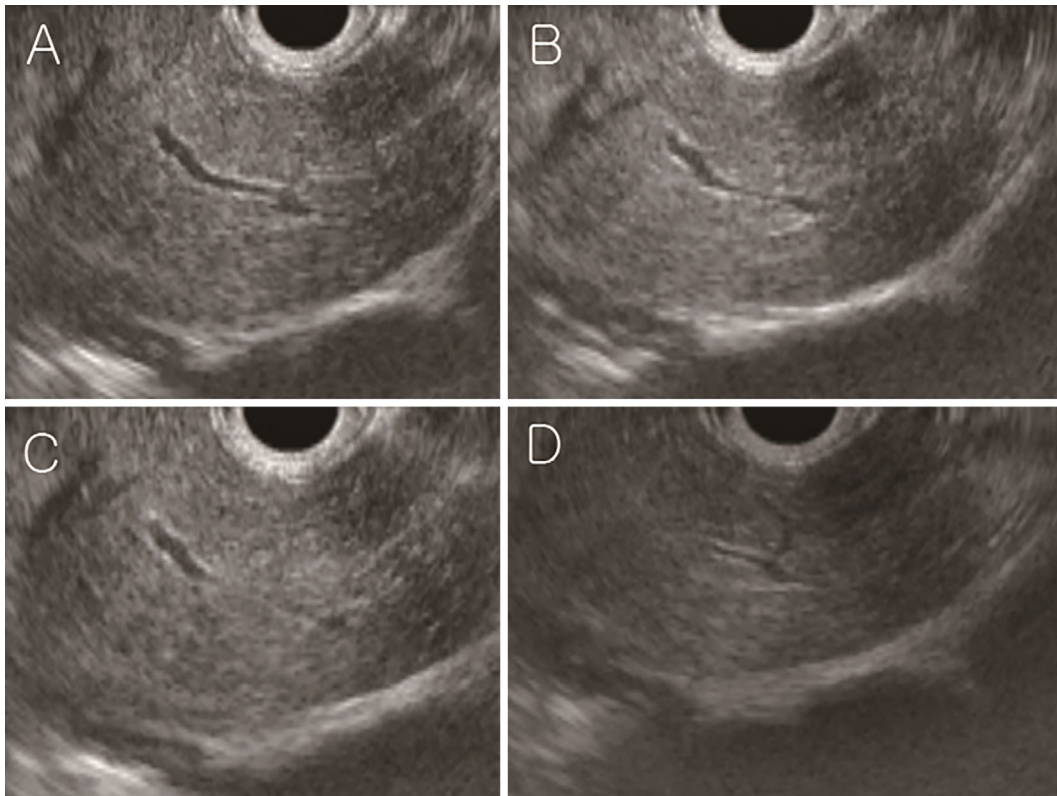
Endoscopic ultrasonography. A: Hyperechoic ductal wall. B: Irregularity of the pancreatic duct. C: Focal stricture of the pancreatic duct without any upstream pancreatic duct dilation. D: Prominent side branches of the pancreatic duct.
